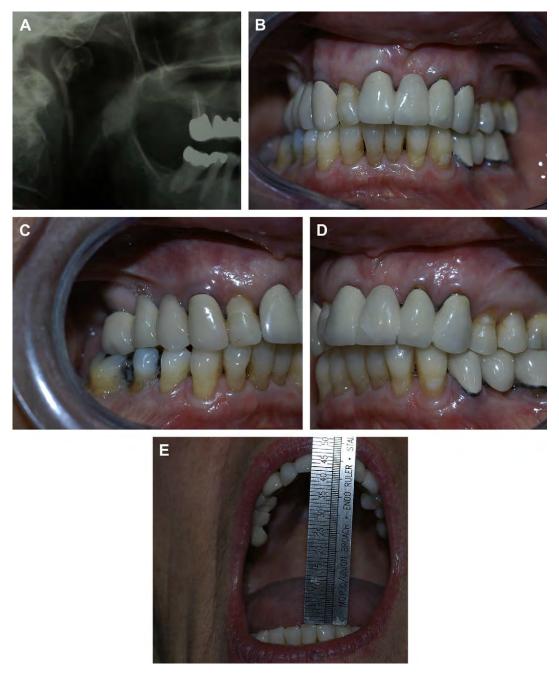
(A-E) Pretreatment panoramic radiograph demonstrating intracapsular fracture of the right condylar head and the 1 year postoperative clinical outcome after closed treatment of the fracture and use of guiding elastics. Note the satisfactory occlusion and maximal incisal opening, but with a deviation of the mandible to the affected side which is otherwise asymptomatic.
